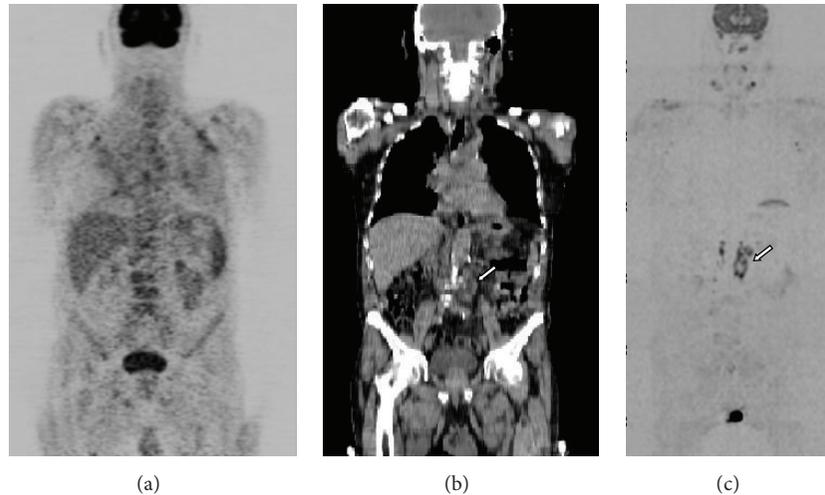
An 82-year-old man with gastric MALT lymphoma: (a) MIP image of ^{18}F -FDG-PET showing no uptake in any lymph node regions, giving stage 0; (b) coronal whole-body CT, showing multiple para-aortic lymph nodes, thus giving stage II (arrow); (c) MIP image of DWI showing the same findings, as high signal intensity in the same nodal location, giving stage II (arrow). However, all techniques, even DWI, failed to find the primary gastric lesion.
